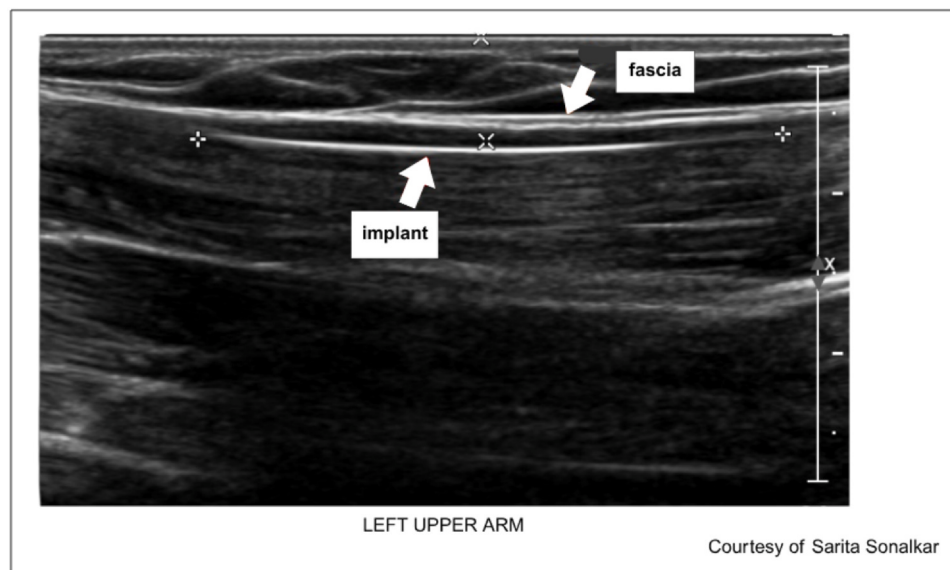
Sagittal ultrasound of subfascial contraceptive implant. The distance between "+" symbols is the measured length of the contraceptive implant (approximately 4 cm). The distance between "x" symbols is the distance from the skin surface to the contraceptive implant (6 mm, in this example).
